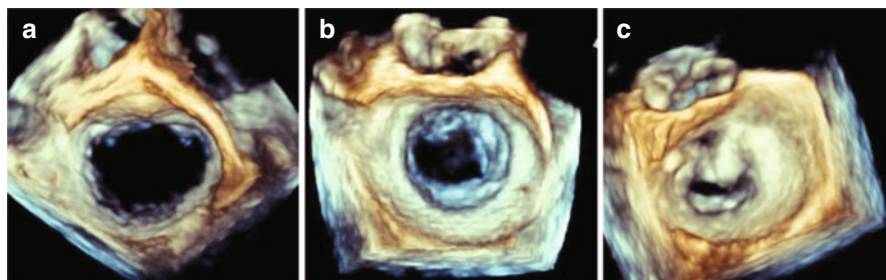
3D echocardiography visualising the mitral valve orifice showing increasing stenosis and deformity of the valve. Image A shows a normal mitral valve appearance; image B shows mild calcification of the mitral valve leaflets; and image C shows severe stenosis affecting the haemodynamics of the mitral valve
